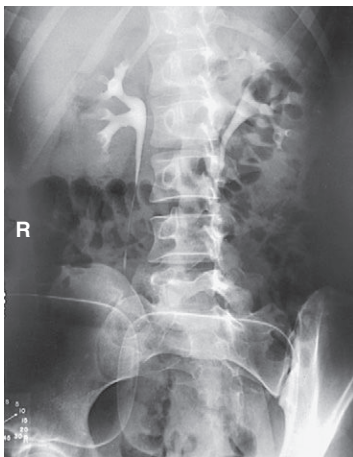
30°—RPO. (From Frank ED, Long BW, Smith BJ: Merrill's atlas of radiographic positioning and procedures, ed 12, St. Louis, 2012, Elsevier.)
